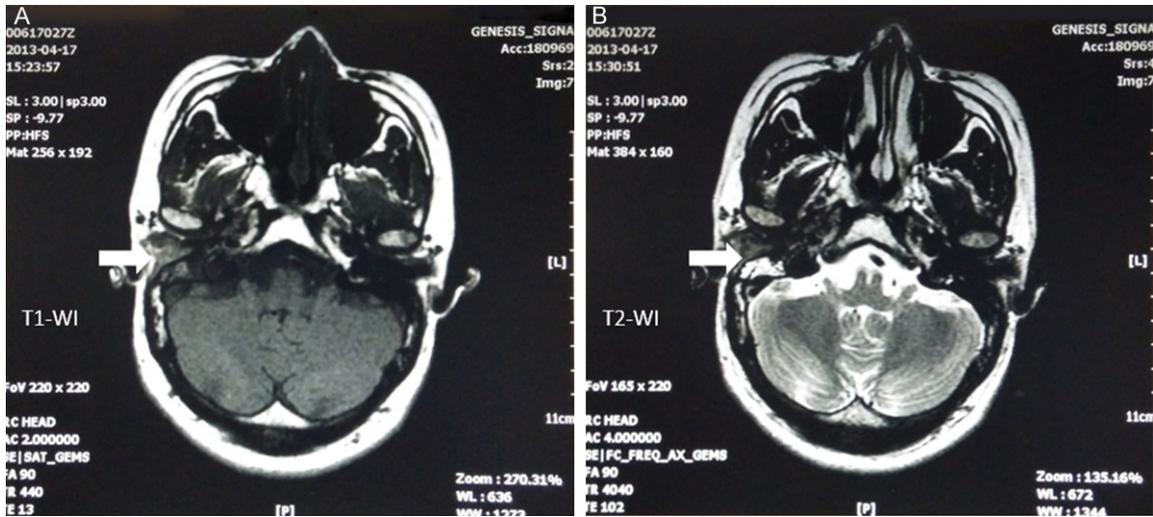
Axial unenhanced MRI scanning show the mean signal intensities on T1-WI and T2-WI in right external auditory canal and mean signal intensity on T1-WI (A) but high signal intensity on T2-WI in right mastoid (B).
